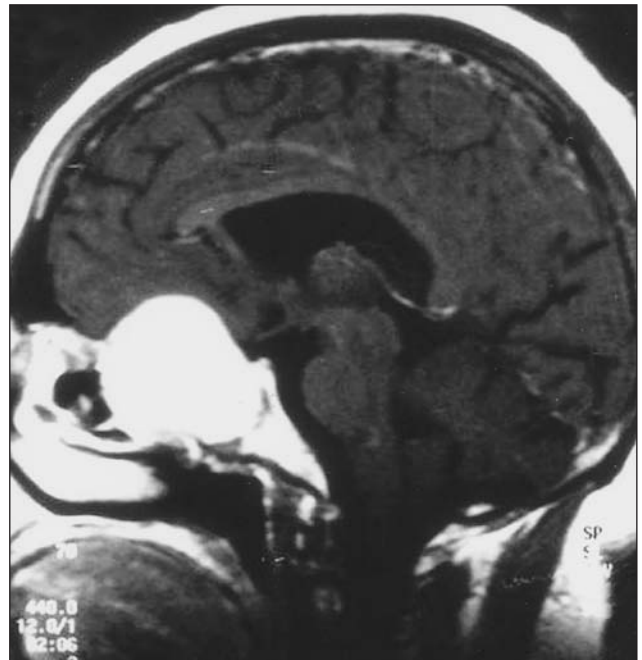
The sagittal T1-weighted MRI scan of the patient showing the contrast enhancing mass lesion in the sella turcica, sphenoid sinus and extending toward the frontal lobe.
